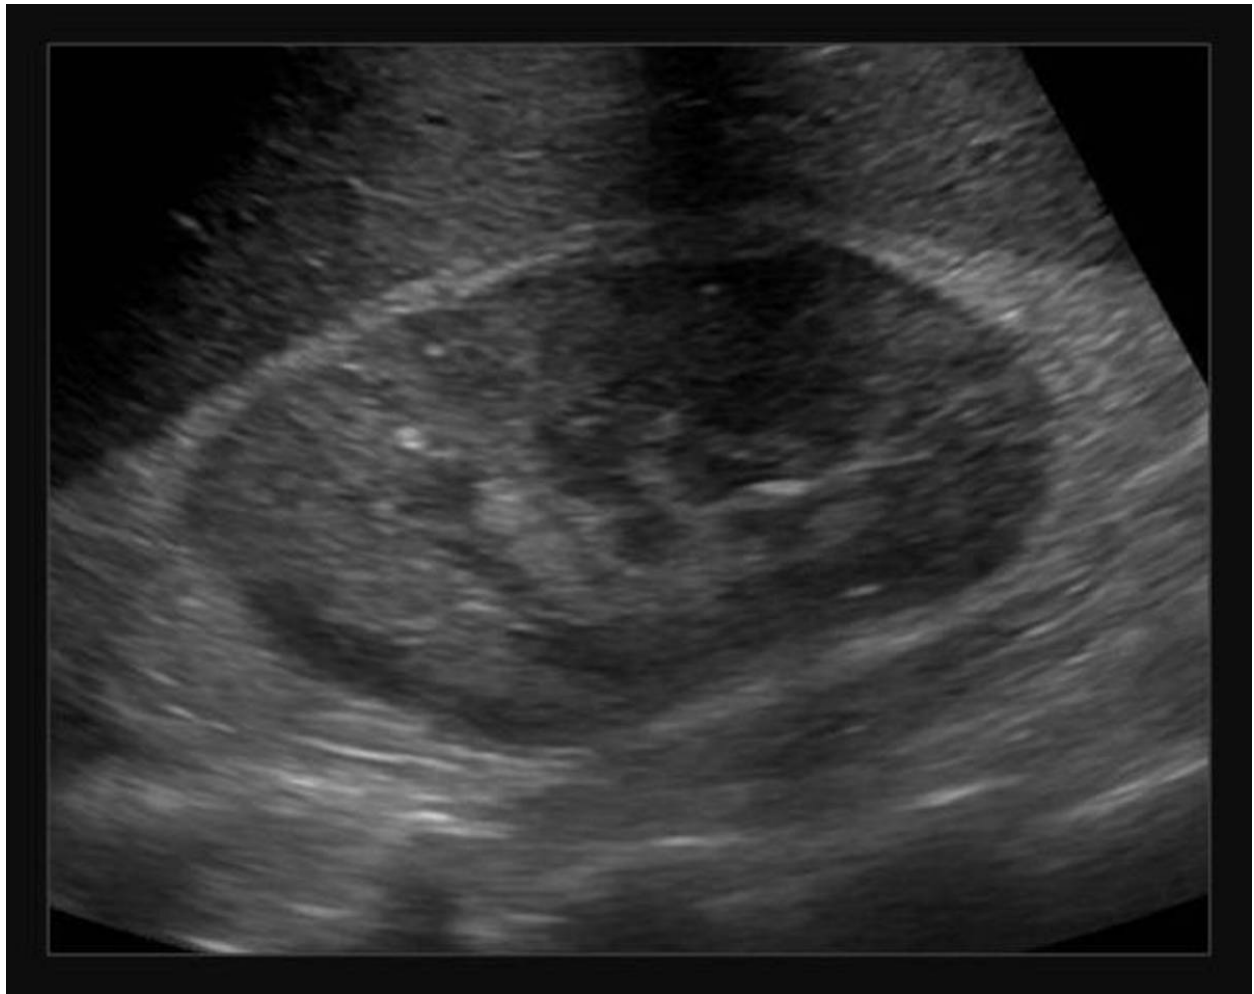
Acute pyelonephritis. Ultrasound scan shows an enlarged right kidney with diffuse hyperechogenicity of the parenchyma and loss of differentiation.
